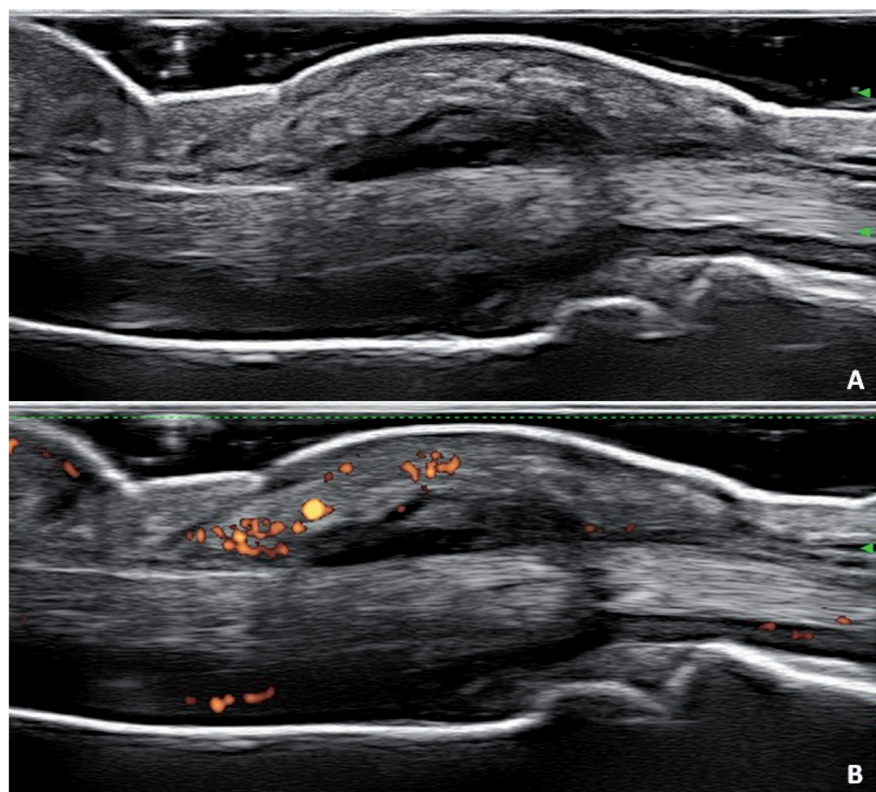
Longitudinal ultrasound views of dactylitis.
